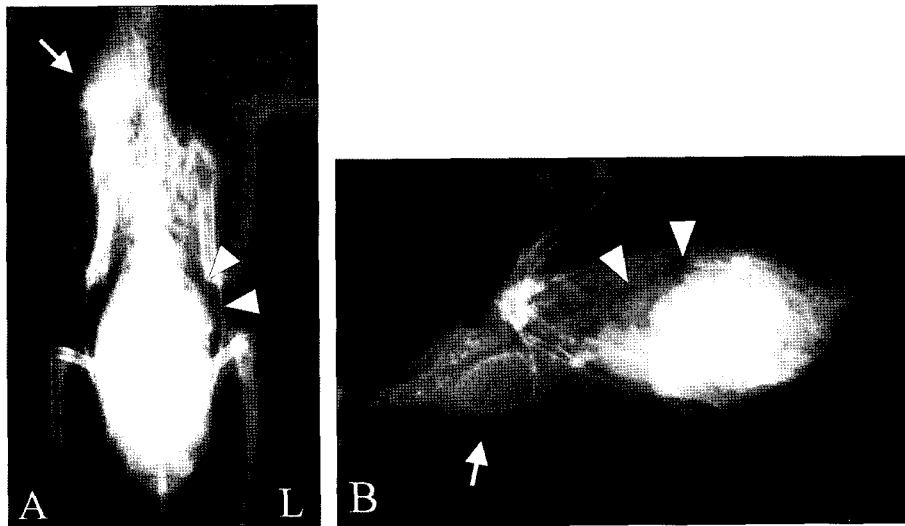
Radiographic examinations. A: Ventrodorsal (VD) view of a parakeet. Dilated crop with air (arrow) and dilated proventriculus (arrow heads) are noted. Decreased size of left abdominal air sac and widening of cardiohepatic angle are detected due to dilated proventriculus. B: Right lateral view of a parakeet. Same as a VD aspect, severely dilated crop with air (arrow), elevation of the proventriculus-ventriculus shadow, and dilated proventriculus (arrow heads) are prominent.
